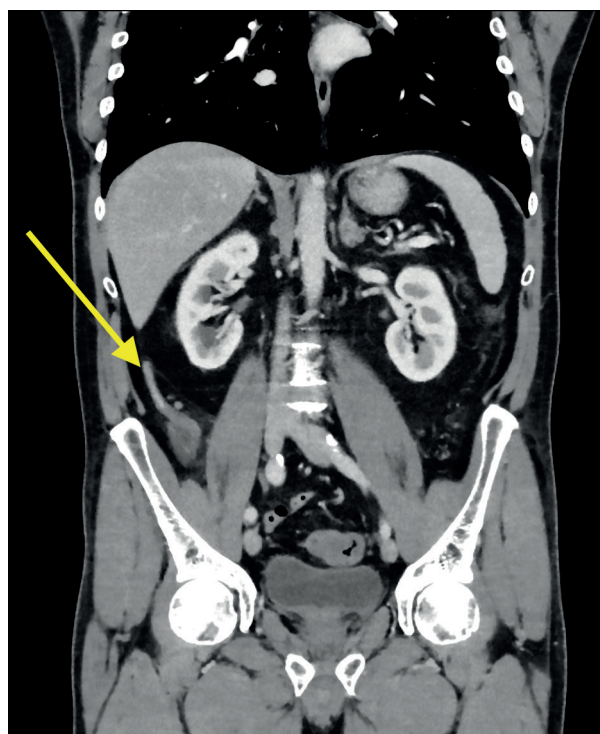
CT image on admission with normal appearance of appendix (yellow arrow).
